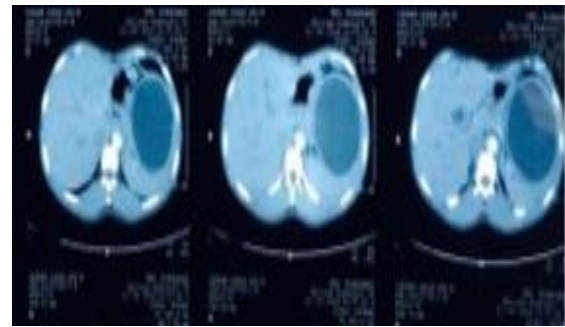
Abdominopelvic computed tomography reveals a giant loculated cystic mass originating from the spleen.
